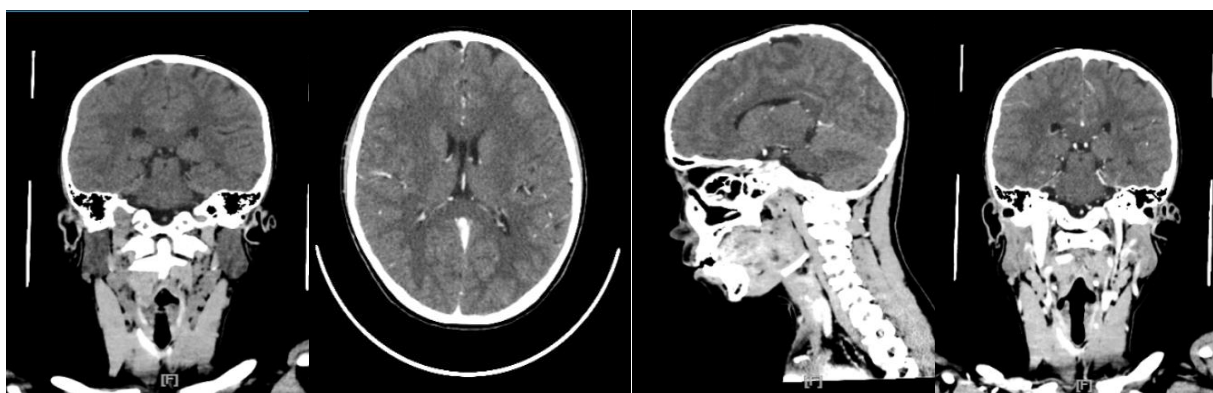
Head and Neck CT Scan Results with Contrast
